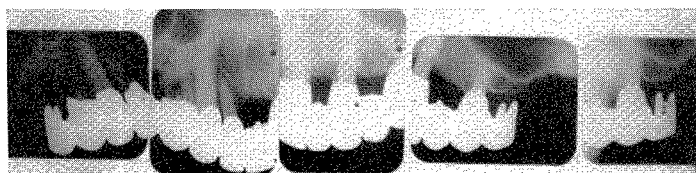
Roentgenograms taken in February, 1958.
